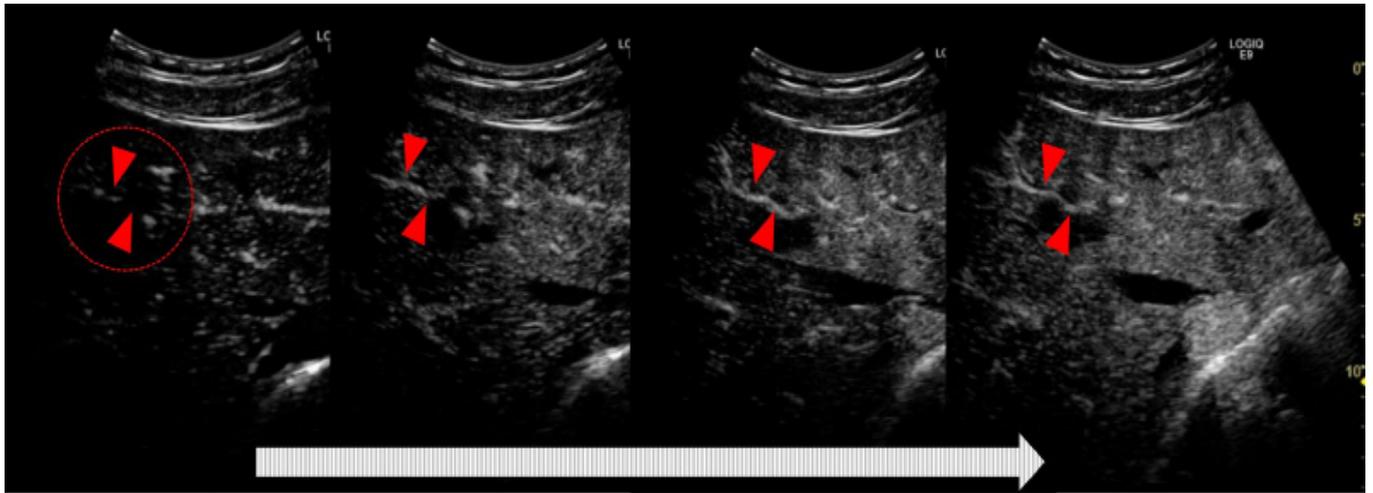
Contrast-enhanced Sonazoid™ ultrasound showing a clear view of vessel penetration through the mass (arrows). The mass is low echogenic with minor enhancement on its margins, but not at the center.
